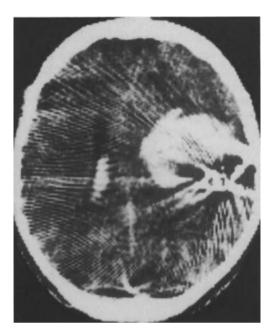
Computed tomogram showing intracerebral hemorrhage 2 weeks later
